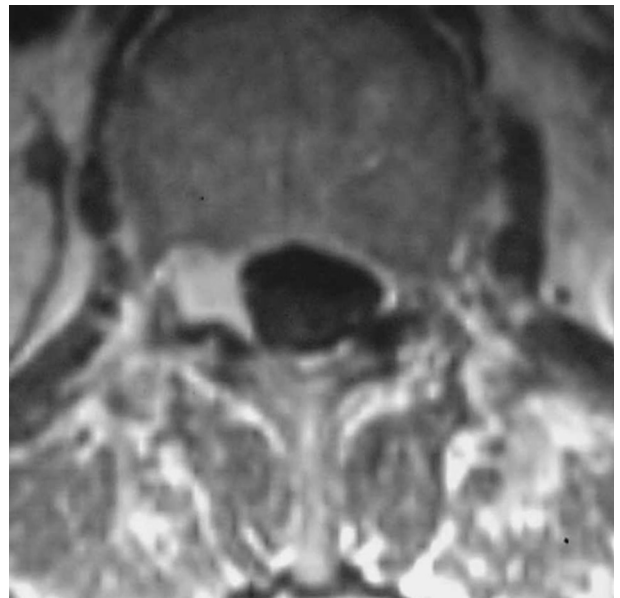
The MRI reveals contrast enhancement of the mass lesion.
